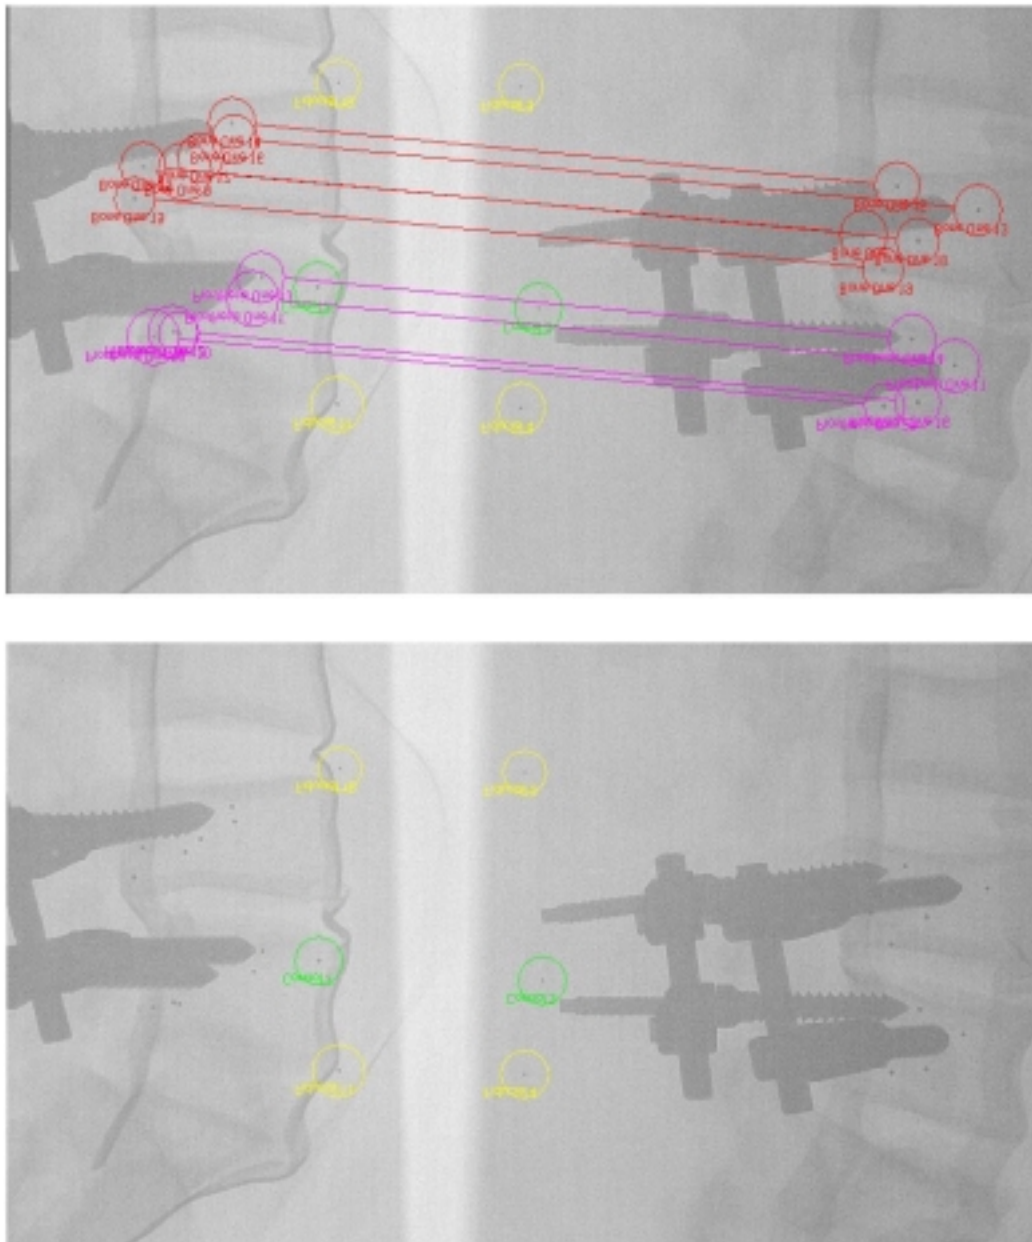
Biplanar radiographic system
